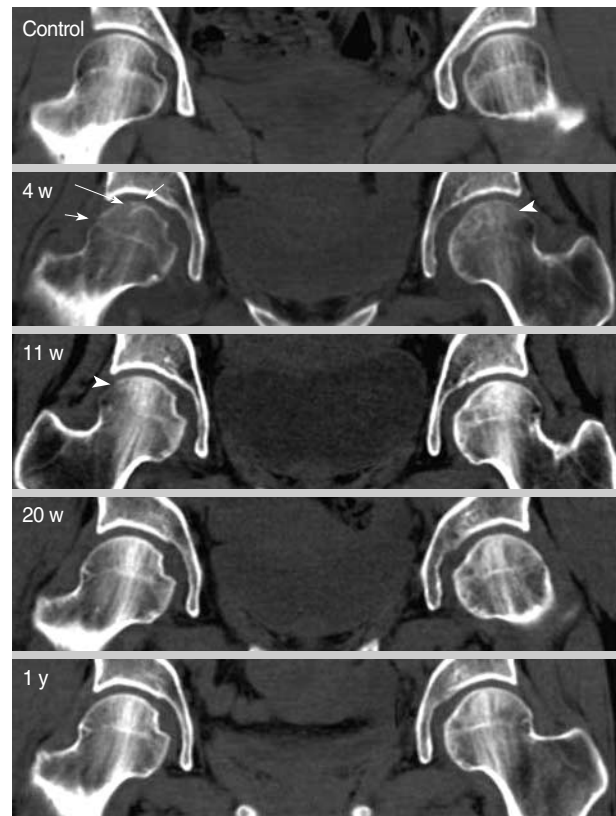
Serial coronal 3D-CT images taken during follow-up are shown. Coronal CT image of a healthy young woman (control) shows well-oriented vertical primary compression trabeculae with normal bone density in both femoral heads. Image obtained at 4 weeks postpartum (4 w) shows reduced bone density in both proximal femurs, and a loss of thickness and continuation of vertical primary compression trabeculae. Area of irregular spotty increased bone density (arrowhead) is observed in the left femoral head immediately below the subchondral bone plate. Breakages of the subchondral bone plate (short arrows) and a sclerotic line (long arrow) obliquely crossing vertical primary compression trabeculae are observed in the right femoral head. Image taken at 11 weeks postpartum (11 w) shows a marked increase in trabecular density in both femoral heads. Area of irregular spotty bone density (arrowhead) is also observed in the right femoral head. Image taken at 20 weeks postpartum (20 w) shows almost normal appearing vertical trabeculae in both femoral heads. The irregular spotty bone density decreased. Image taken at one year postpartum (1 y) shows normalized vertical trabeculae in both femoral heads. The irregular spotty bone density has decreased further at this stage.
